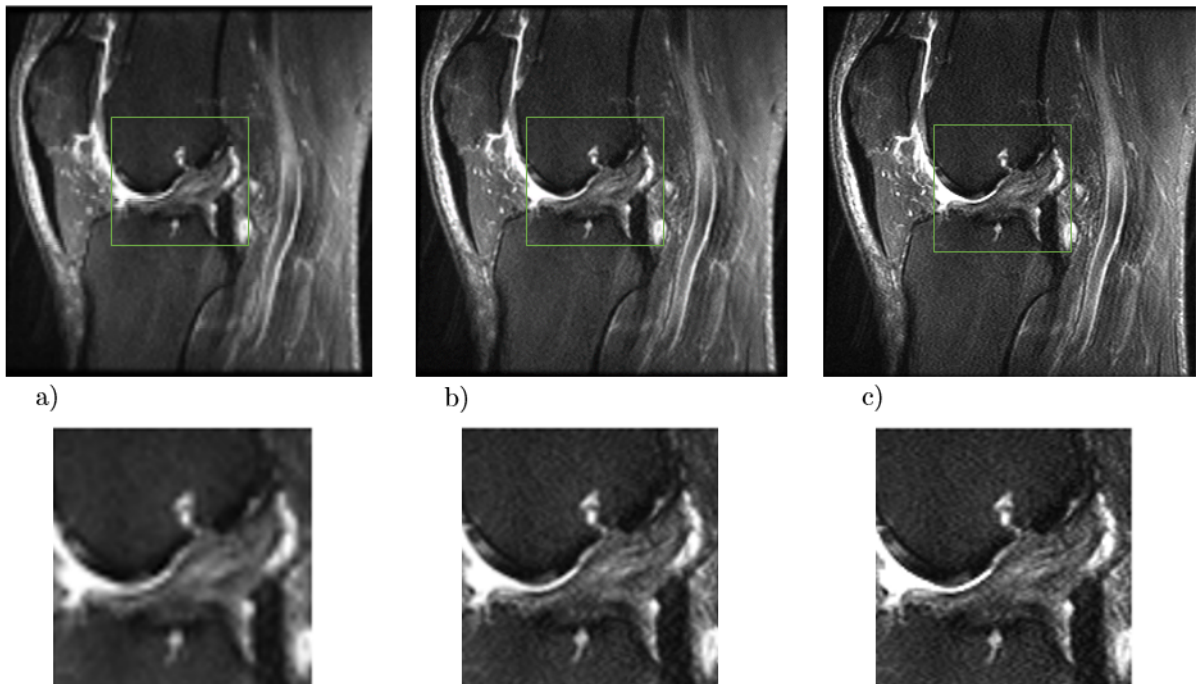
Sagittal T2 MRI. a) LR full and crop images. b) SR full and crop images. c) HR full and crop images. [33]
